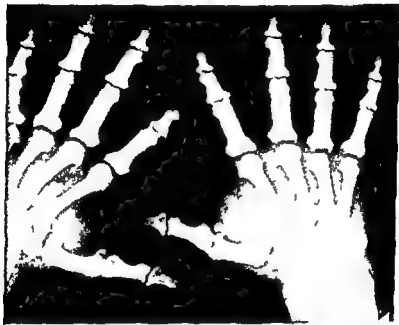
X-ray study of hands in acromegaly. Note characteristic cauliflower like appearance of terminal phalanges caused by lateral tufting. There is also some general widening of the bones. (After R. F. Escamilla, *Diseases of the Pituitary* in *Musser Wohl Textbook of Internal Medicine*, 5th Edition, Philadelphia, Lea and Febiger, 1951.)
